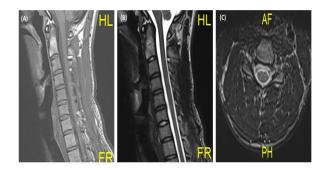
Sagittal turbo spin echo (TSE) T1 (A), sagittal turbo spin echo (TSE) T2 (B), axial turbo spin echo (TSE) T2 (C) images are seen as normal in standard cervical MRI protocol.
